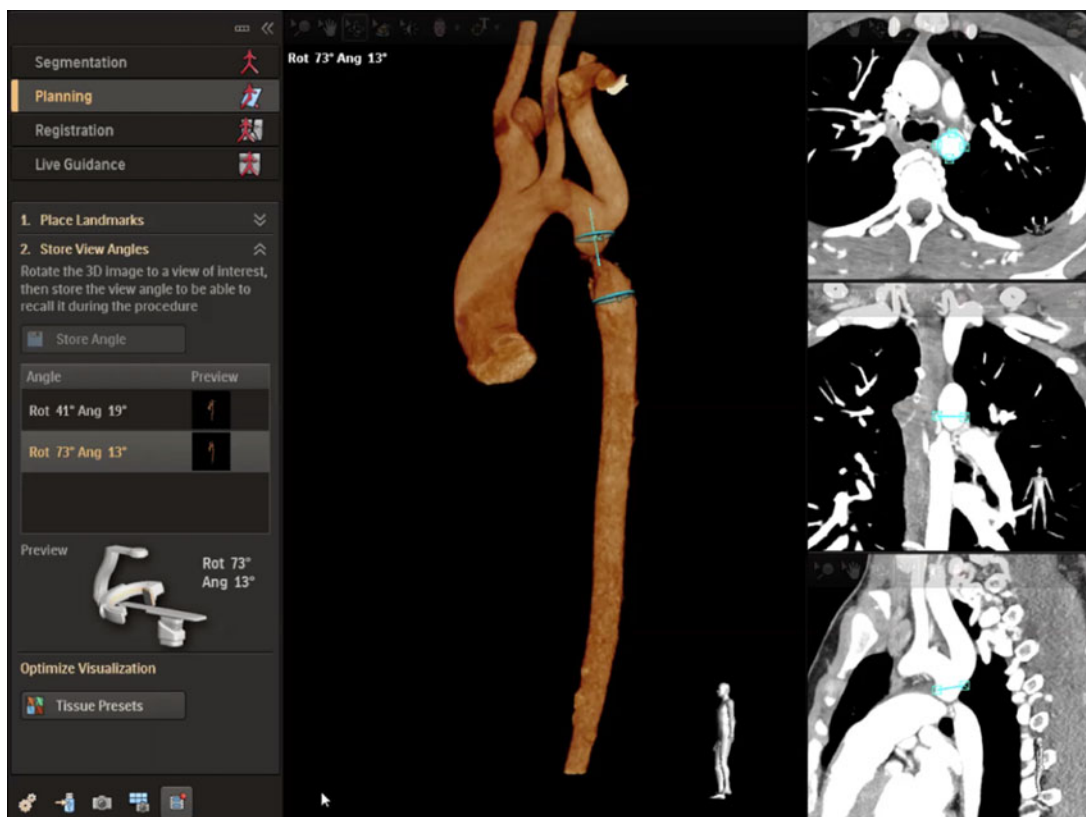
Segmentation and planning process is shown. CT images (right) are segmented (light blue) to create a 3D reconstruction. A preview is available for the interventionist's camera (bottom left) to ensure the image overlay image is feasible with the patient on the table.
